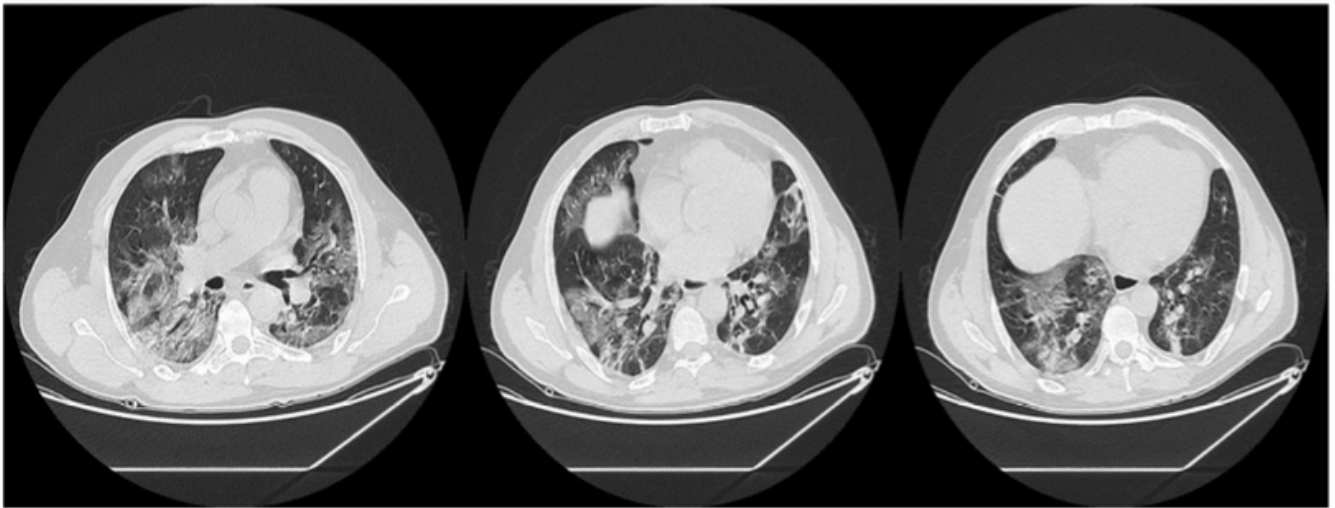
The chest CT scan on admission : bilateral and basal peripheral involvement, frosted glass, and crazy paving aspect and multifocal condensates
